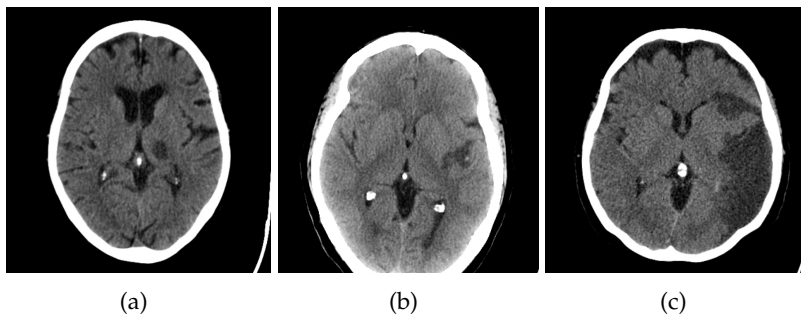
Some of the typical radiographic features of stroke observed in three different patients on CT scans: (a) left thalamic hypodense focus developed during 24 hours after stroke onset (image and description source: case courtesy of David Cuete, radiopaedia.org, rID: 36507), (b) a small irregular hypodense area seen at the left temporal region with loss of grey-white matter differentiation (image and description source: case courtesy of Rania Adel Anan, radiopaedia.org, rID: 99808), (c) extensive infarction in the territory of the left middle cerebral artery (image and description source: case courtesy of David Cuete, radiopaedia.org, rID: 35732)
